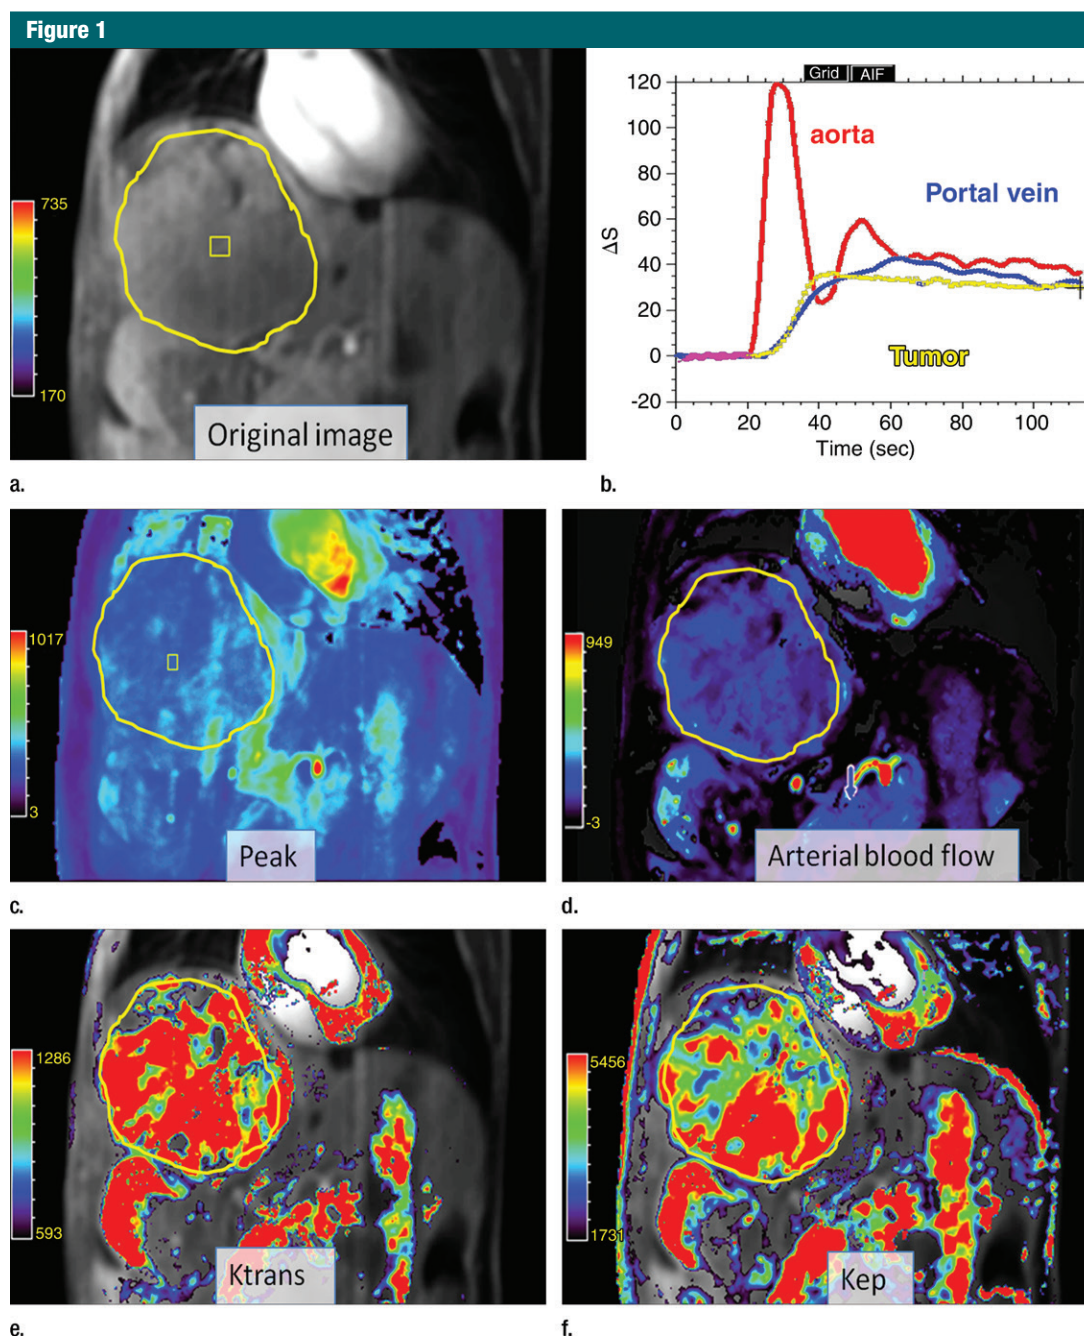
Advanced HCC in a 68-year-old man. (a) Contrast-enhanced T1-weighted MR image shows a large tumor in the right upper lobe of the liver. (b) Graph shows enhancement curves of the aorta (red line), portal vein (blue line), and tumor (yellow line). (c–f) DCE MR images with color maps for (c) peak, (d) AF (mL/100 g/m), (e) K^{trans} ($m^{-1}/1000$), and (f) reverse volume transfer constant ($m^{-1}/1000$) show that the tumor has increased perfusion, AF, and permeability compared with the background liver.
